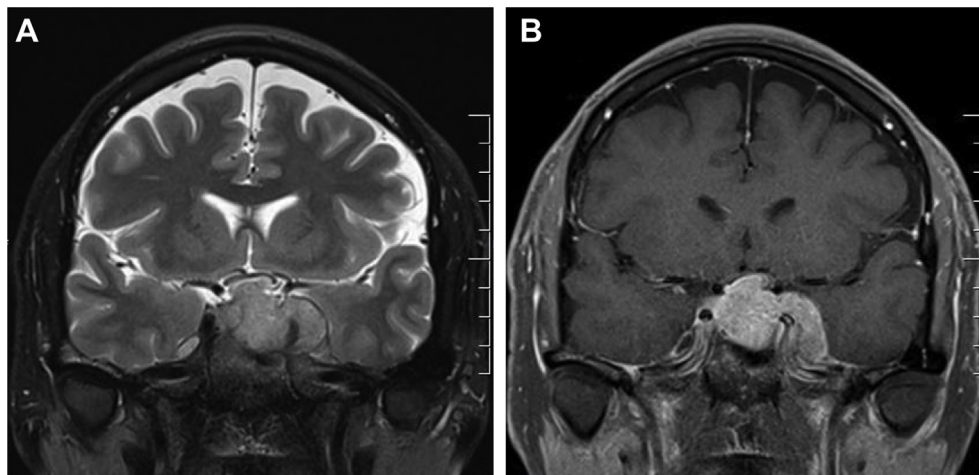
MRI of the Orbits for Suspected Optic Chiasm Compression. A) Coronal T2-weighted MRI image demonstrating a large pituitary mass extending into the left cavernous sinus and compressing the optic chiasm, primarily on the left side. B) Coronal T1-weighted MRI image post-contrast showing enhancement of the tumour with gadolinium.
